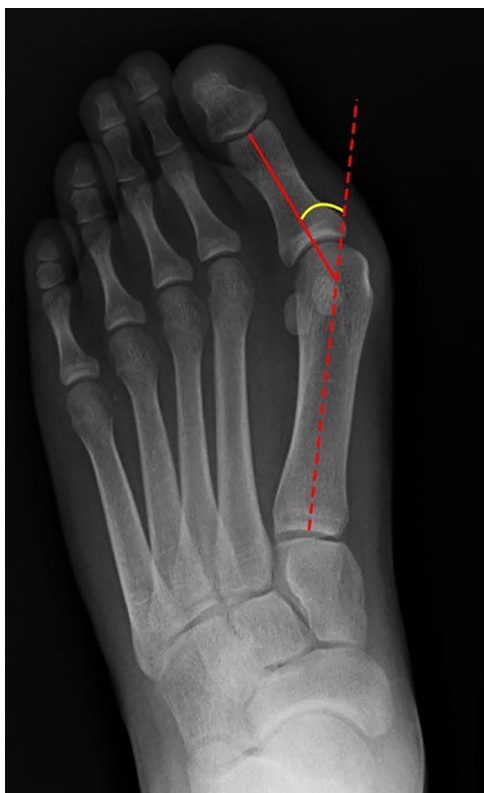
Plain radiograph showing hallux valgus angle of the first metatarsal.
